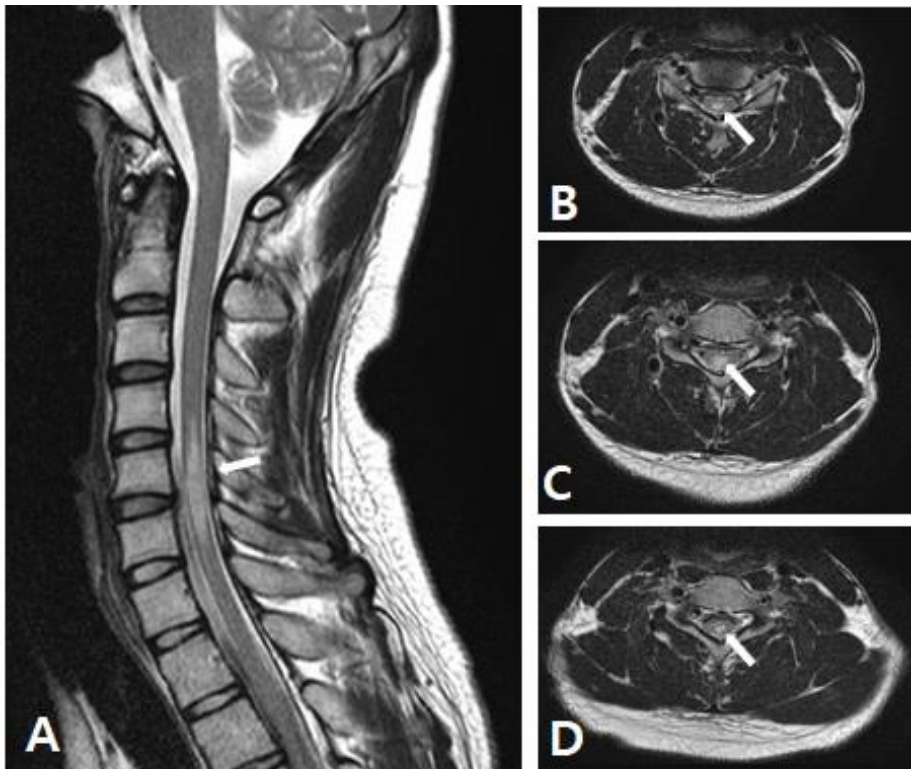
Magnetic resonance image (MRI) of cervical spinal cord. (A) High signal intense area (white arrow) of demyelination is seen at cervical spinal cord on T2-weighted sagittal image. (B-D) High signal intense area (white arrows) of demyelination is seen at fourth (B), fifth (C), and sixth (D) cervical levels of spinal cord on T2-weighted axial images
